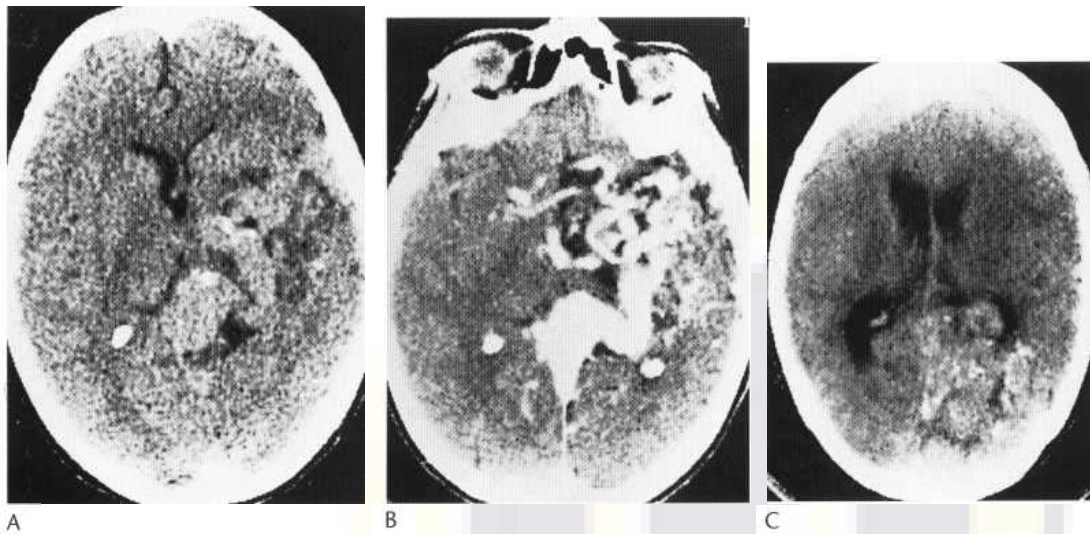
(A) Large temporal angiomatous malformation. Note mottled appearance. The dilated vessels are of slight increased density and there are small 'cystic' and low-density areas. (B) After contrast medium, the dilated serpiginous vessels are well shown. Major drainage is to an aneurismal vein of Galen. (C) Large occipital angioma. CT shows mottled area of mixed high and low densities with flecks of calcification. (D) After enhancement multiple dilated vascular shadows are shown.
